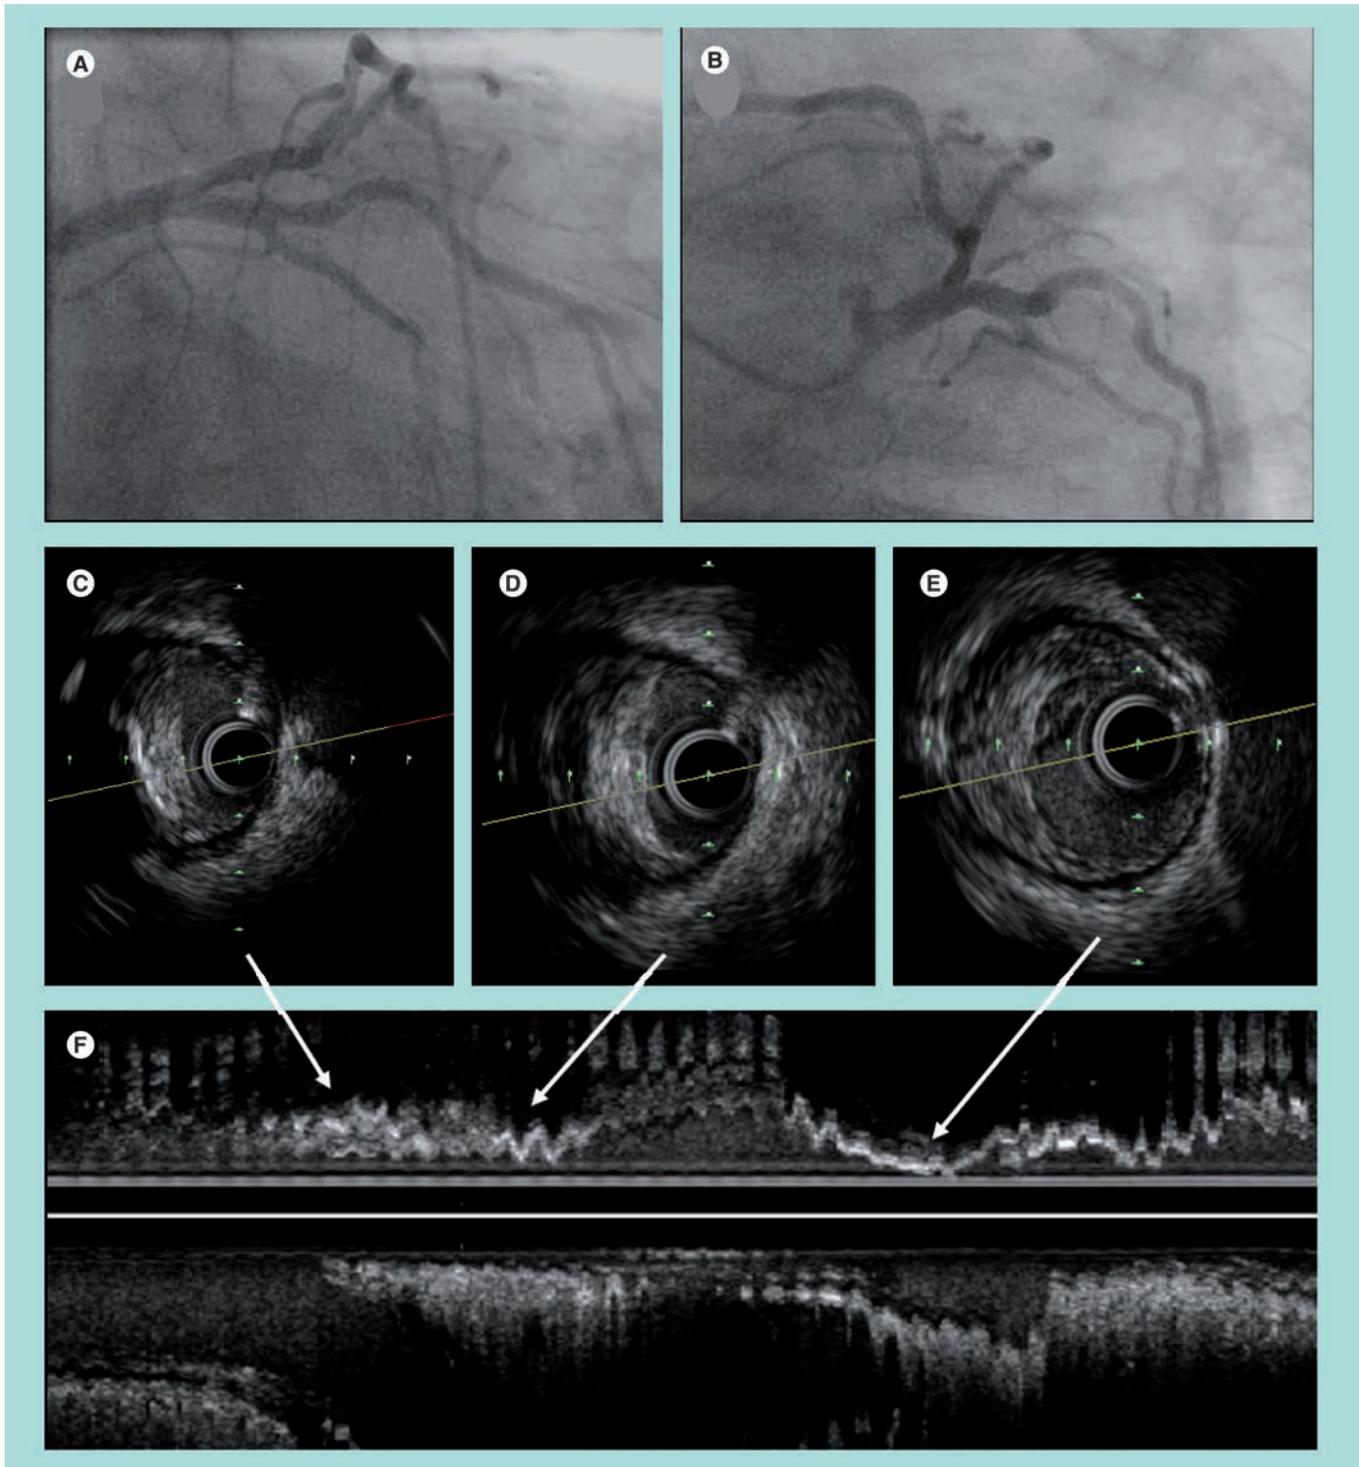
A 65-year-old woman presenting with progressive shortness of breath and chest pain. (A & B) Coronary angiogram showed the presence of mild disease involving the proximal left anterior descending artery segment. Intravascular ultrasound imaging of the left anterior descending artery showed the presence of an excentric, mixed plaque that determined a severe stenosis in the proximal segment ([C & D] show cross-sectional views, and [F] shows long-run view), and a more distal, soft plaque ([E & F] show cross-sectional and long-run views, respectively), also missed by the angiography.
